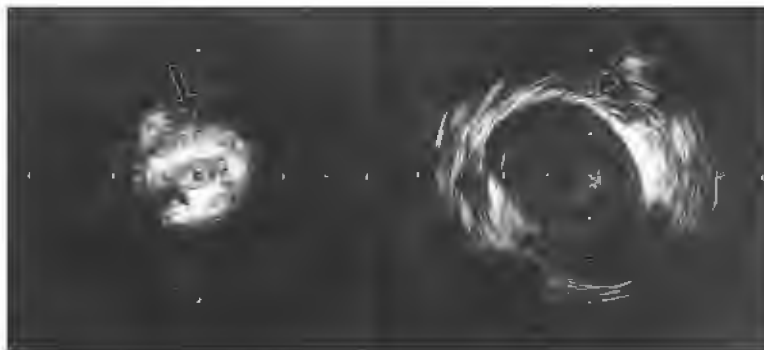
Intravascular ultrasound scan images show different degrees of outside compression of left common iliac vein as it is crossed by right common iliac artery (*a*). Position of iliac artery depends on orientation of catheter (*black circle inside vein*) and does not necessarily reflect anatomic topography.
